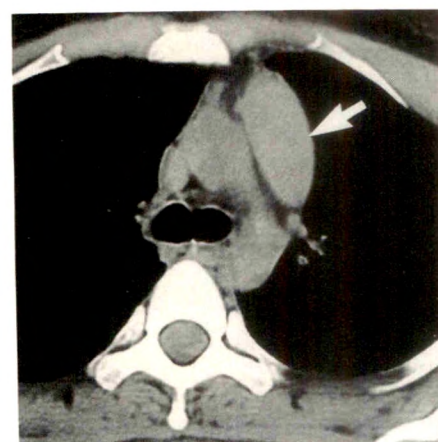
26-year-old woman with non-Hodgkin lymphoma who had extensive adenopathy of anterior mediastinum before treatment. After radiation therapy and remission, CT scan shows left lobe of thymus (arrow), which remained enlarged but unchanged during a 12-month interval.
